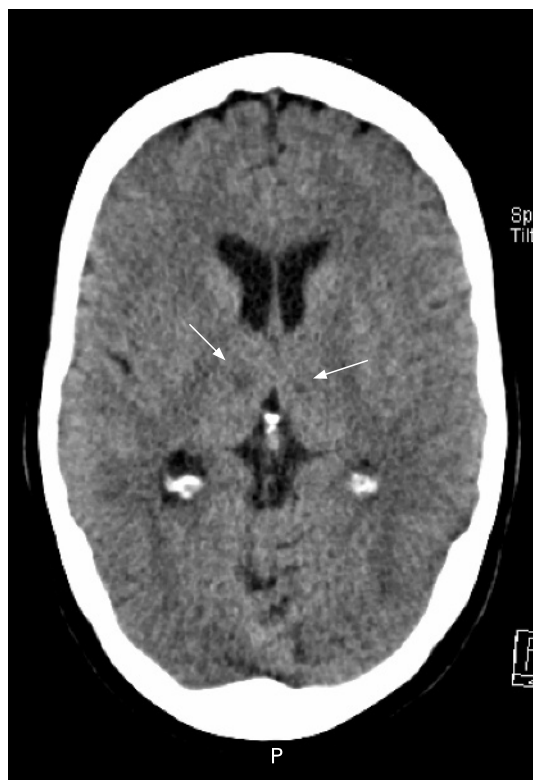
Brain computed tomogram, showing bilateral low-intensity lesions in the thalami (arrows).
